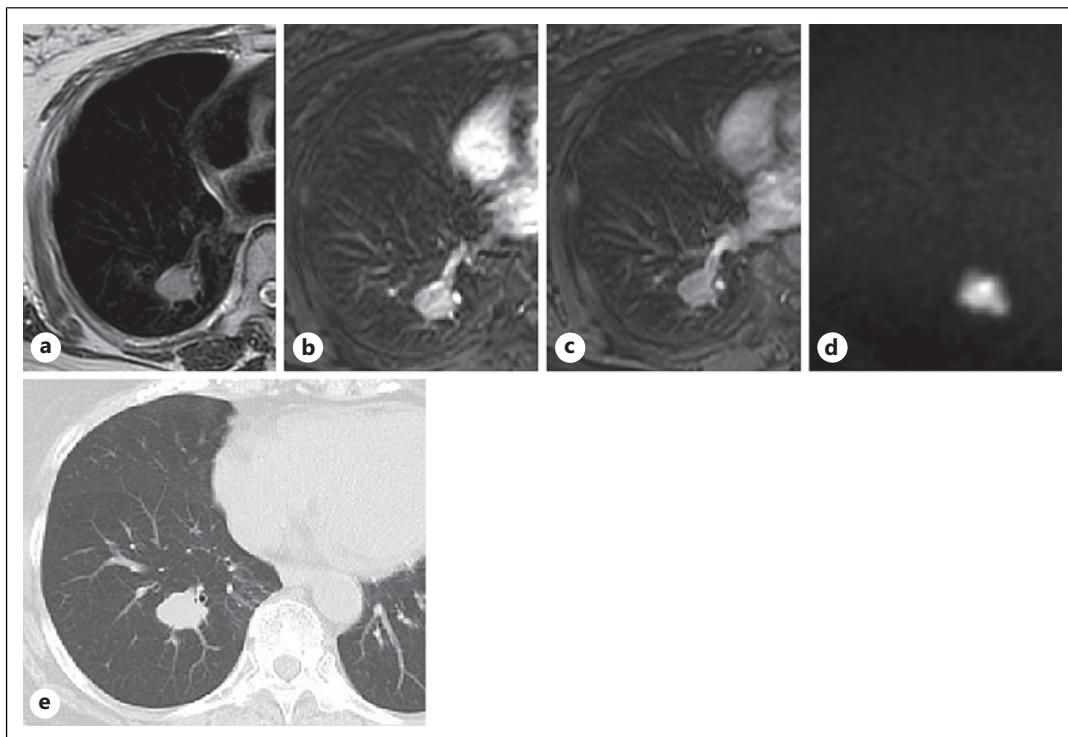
Imaging of the lung mass appearing 13 months after RFA. T2-weighted (a), arterial phase (b), portal phase (c), and diffusion-weighted image (d) of Gd-EOB-DTPA-MRI; plain CT (e).
